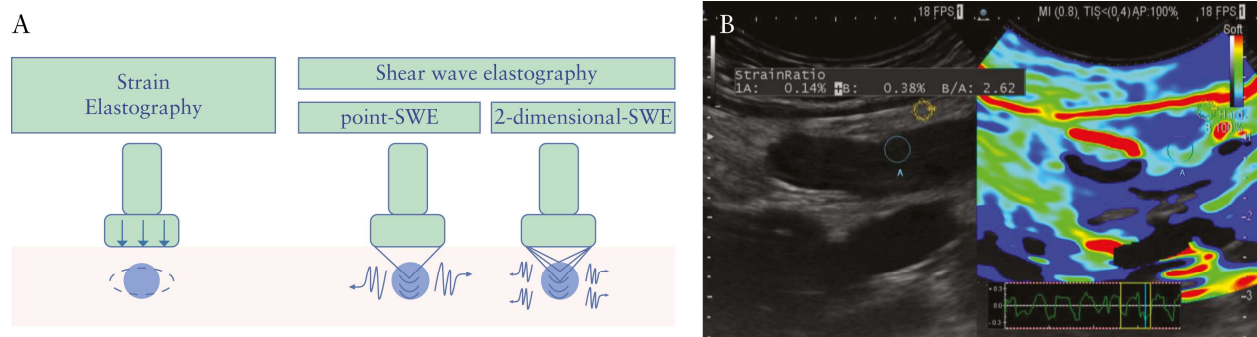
Technique and principles of ultrasound elastography. A. The technologies currently used and commercially available in ultrasound [US] machines are divided into two main types: strain [SE] and shear wave elastography [SWE]. In SE, the induced tissue displacement is traced between pairs of echo frames, then the strain is calculated from their gradient. Technically, two SWE methods can be distinguished: the point-SWE [pSWE] and the 2-dimensional-SWE [2D-SWE]. In the p-SWE, the speed of shear wave is measured in a single specific location [ROI]; the 2D-SWE produces a quantified colour map of the distribution of shear wave velocities in a wider region. B. An example of SE applied to bowel wall is shown. SWE: shear wave elastography (20).
